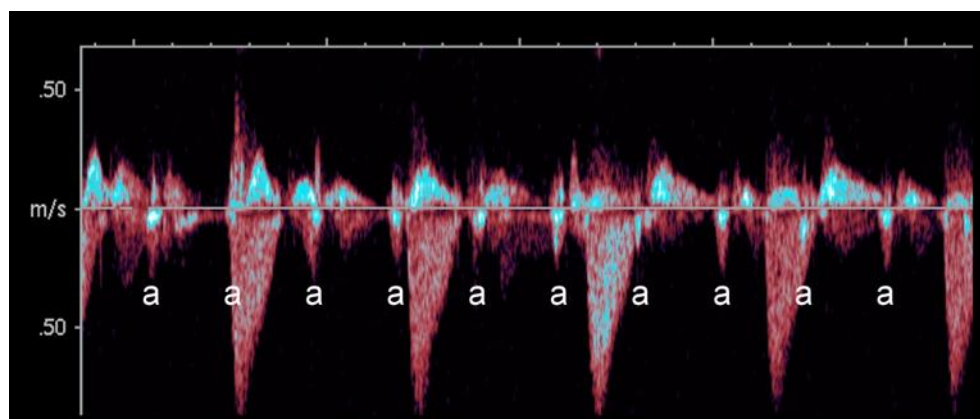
Doppler recording from vena cava superior (above the baseline) and aorta (flow directed inferiorly) showing a complete heart block with a slower ventricular rhythm and the clearly visible atrial contractions (a) even during ventricular systole.
